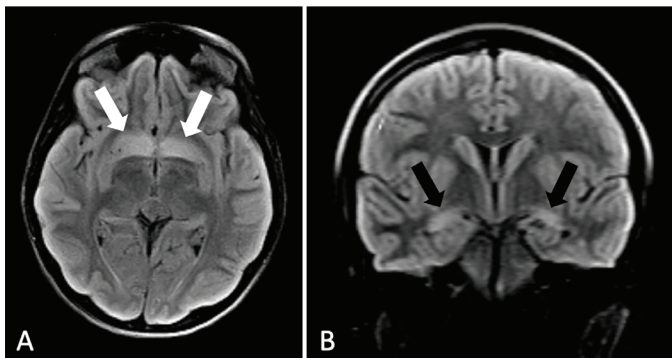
(A) Axial T2-FLAIR shows bilateral symmetric T2 signal enhancement in the globus pallidus (filled white arrows) (B) Coronal T2-FLAIR shows cortical swelling and T2 signal enhancement suggestive of bilateral hippocampal involvement (filled black arrows). T2-FLAIR: T2-fluid-attenuated inversion recovery
